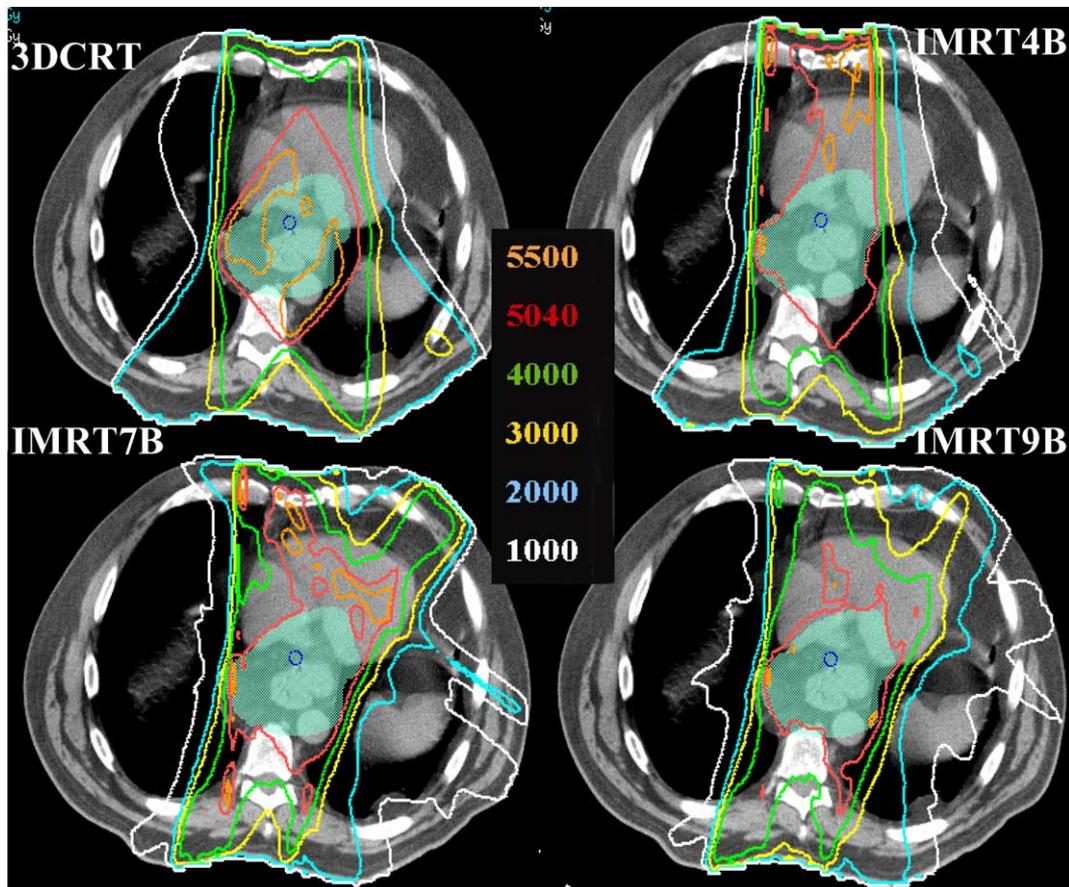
Sample transverse CT images showing the isodose distributions in the middle of PTV for one of the cases studied.
